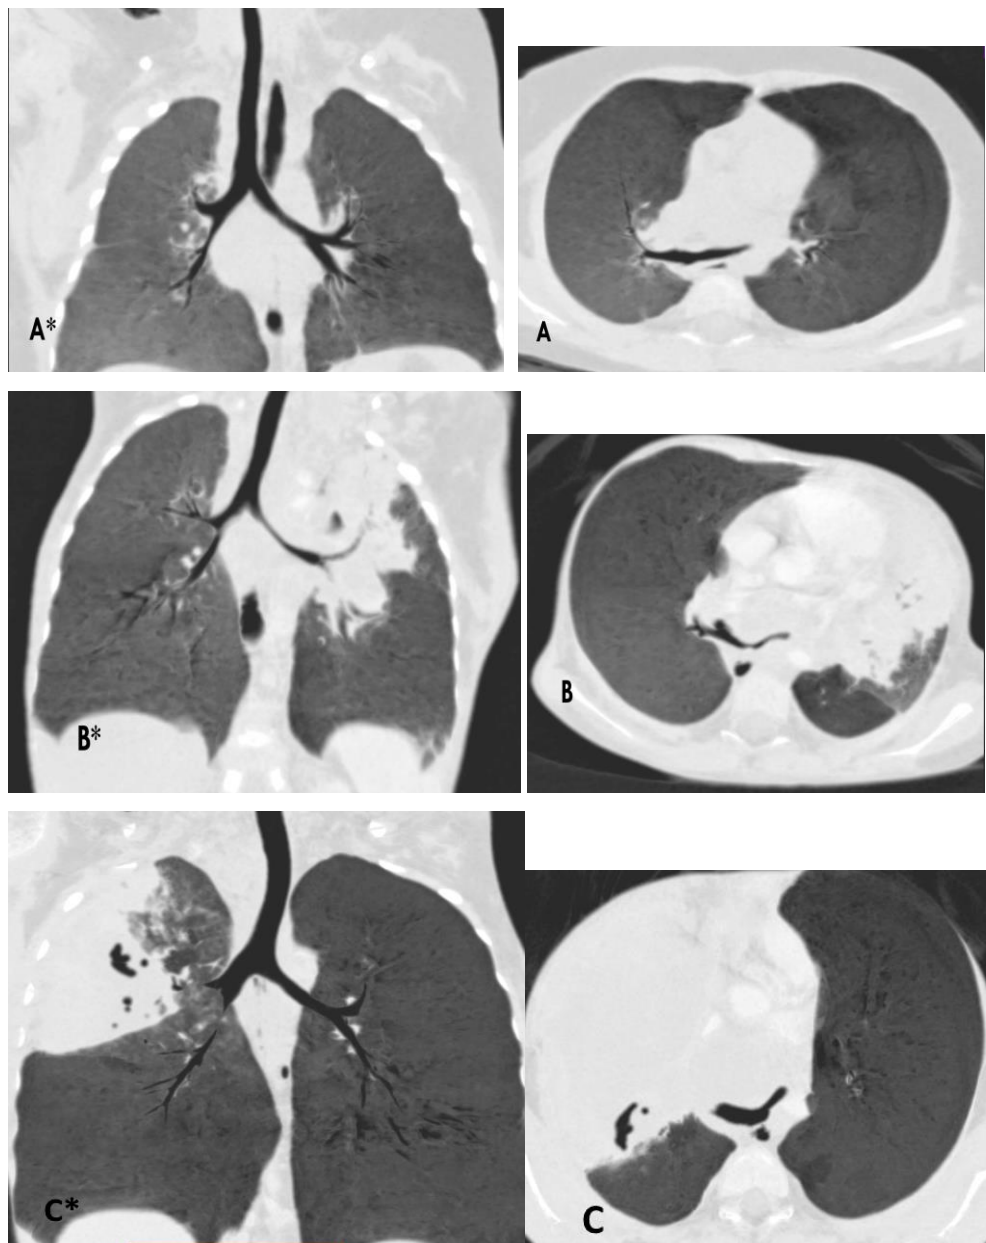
Three examples where the carina was considered normal on coronal CT MinIP but was determined to be abnormal on the axial CT MinIP
